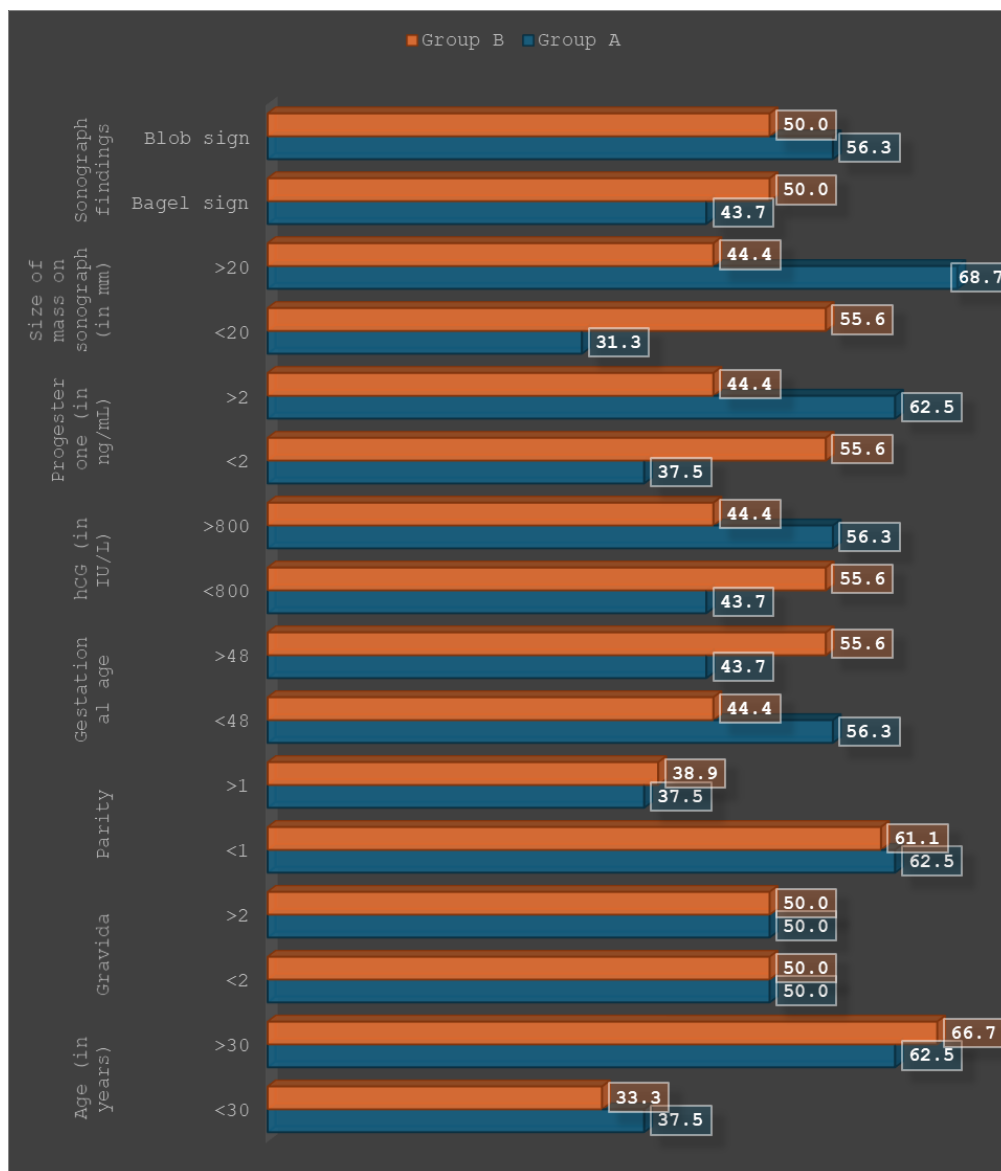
Comparison of successful outcomes in Group A and Group B by patient characteristics (sociodemographic obstetric, laboratory, and sonographic)
